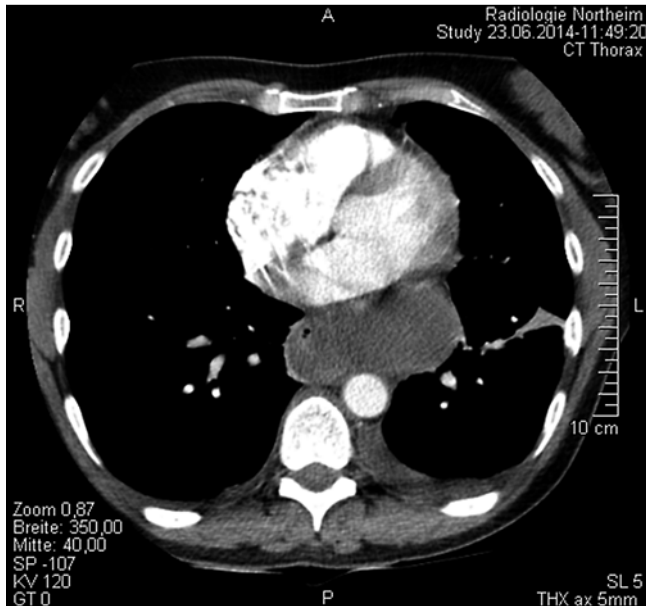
Computed tomography (CT) scan in a 47-year-old woman with an asymptomatic bronchogenic cyst shows the cyst with dislocation and compression of the esophagus.
